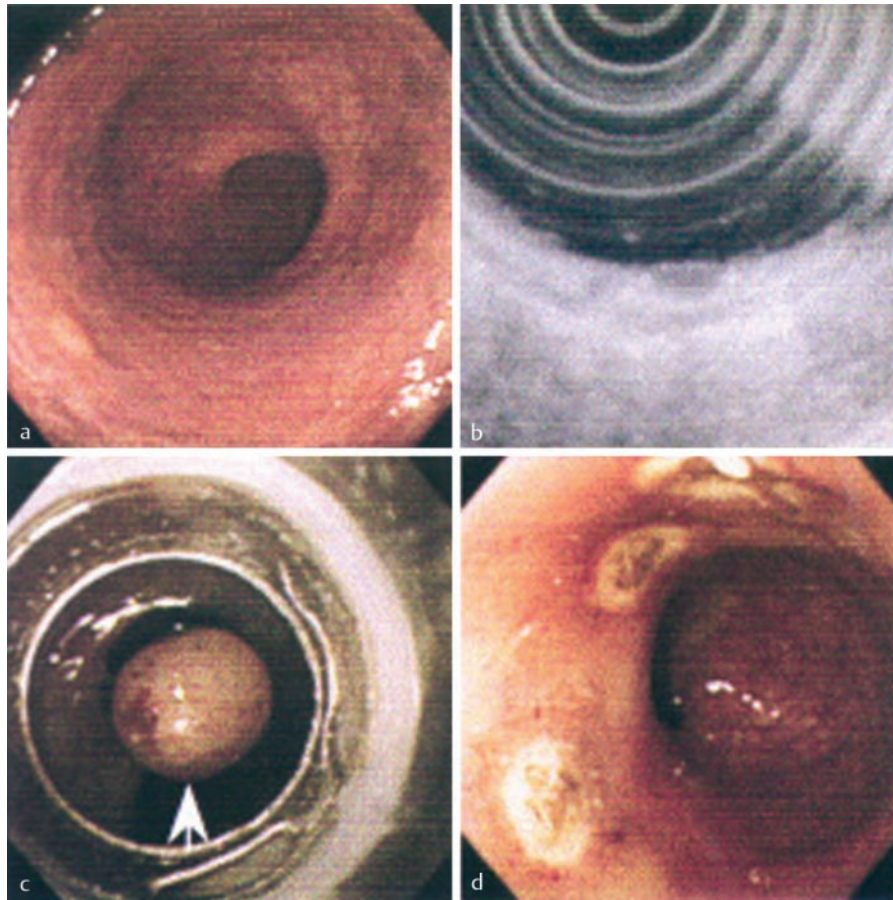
Rectal carcinoid tumors. a Endoscopic appearance before resection. b Endoscopic ultrasonogram before resection. c Mucosal resection of a carcinoid nodule (arrow) using an esophageal variceal ligation device. d Endoscopic view after resection.
